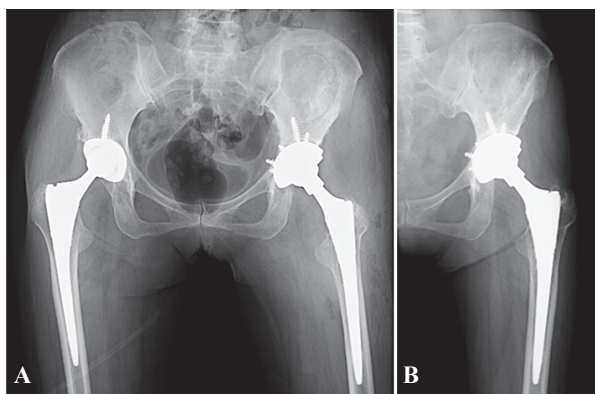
Progression of preoperative plain radiographs. A. Postoperative radiograph after left primary total hip arthroplasty (THA) with non-cross-linked ultra-high molecular weight polyethylene (UHMWPE). B. The 11-year follow-up radiograph after surgery. Cup side: osteolysis in Zone 1 (arrow), Stem side: osteolysis in Zone 1 (arrow-head). C. The 12-year follow-up radiograph after surgery (just before revision THA). This radiograph showed a huge osteolytic lesion in the left iliac (arrowheads) and expanded osteolysis in Zone 1 of cup side. The femoral head was eccentric relative to the central point of the cup because of excessive wear of the polyethylene. UHMWPE: ultra-high molecular weight polyethylene.
